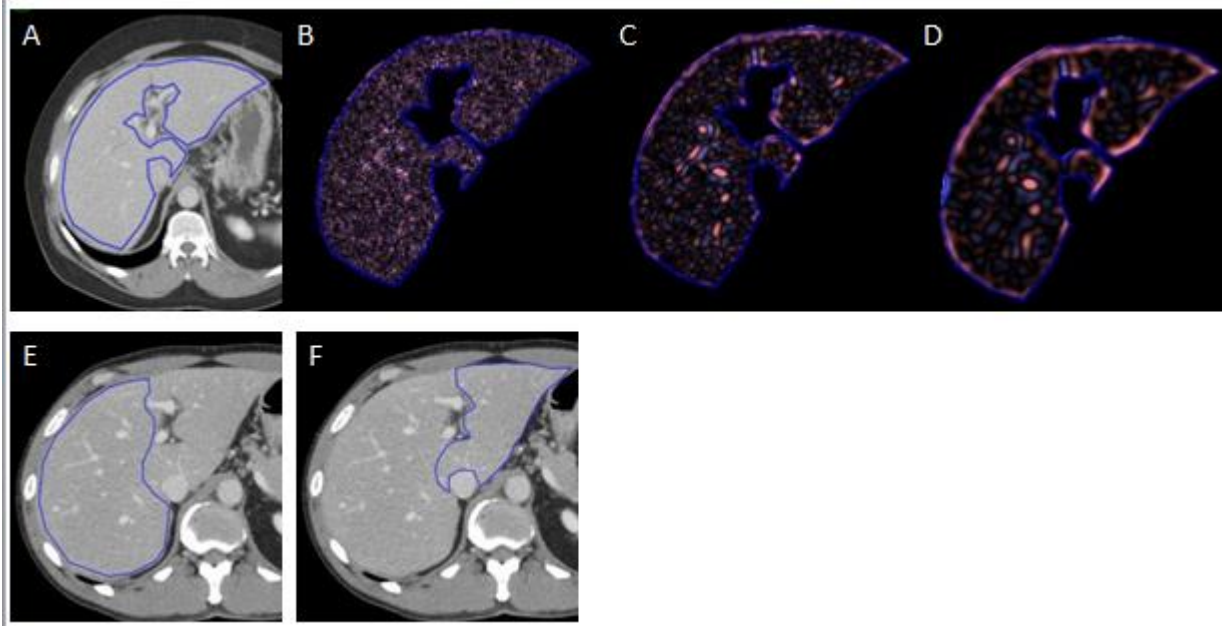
Texture measurements of the liver. Single slice CT image demonstrates an ROI drawn around the total liver at the level of the porta hepatis (A) in a pt with F3 disease. Fine (B), medium (C) and coarse filter (D) texture output is obtained. Similarly, ROIs were placed on segments IV-VIII (E) and segments I-III (F) for additional analysis.
